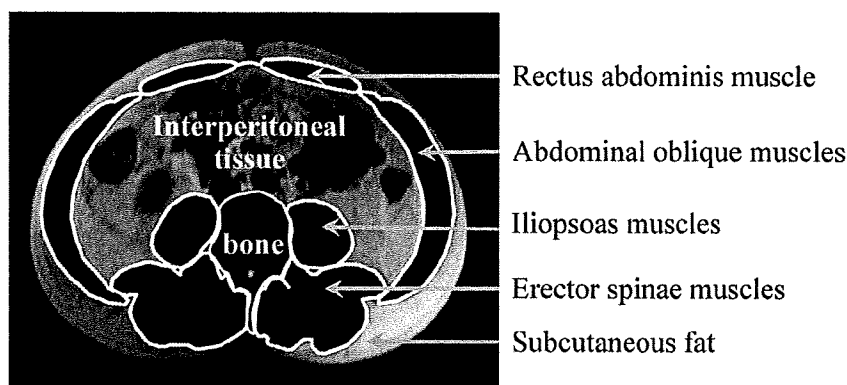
Abdominal MRI image obtained from the umbilicus level.
